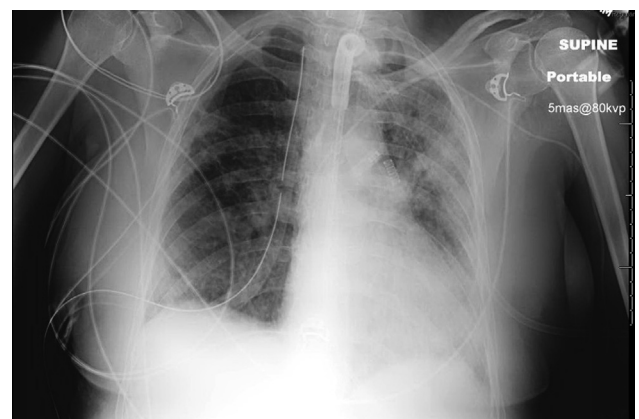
Chest radiograph shows significant improvement in the bilateral infiltrates and subcutaneous emphysema. The double lumen endotracheal has been removed and a tracheostomy tube has been placed.
